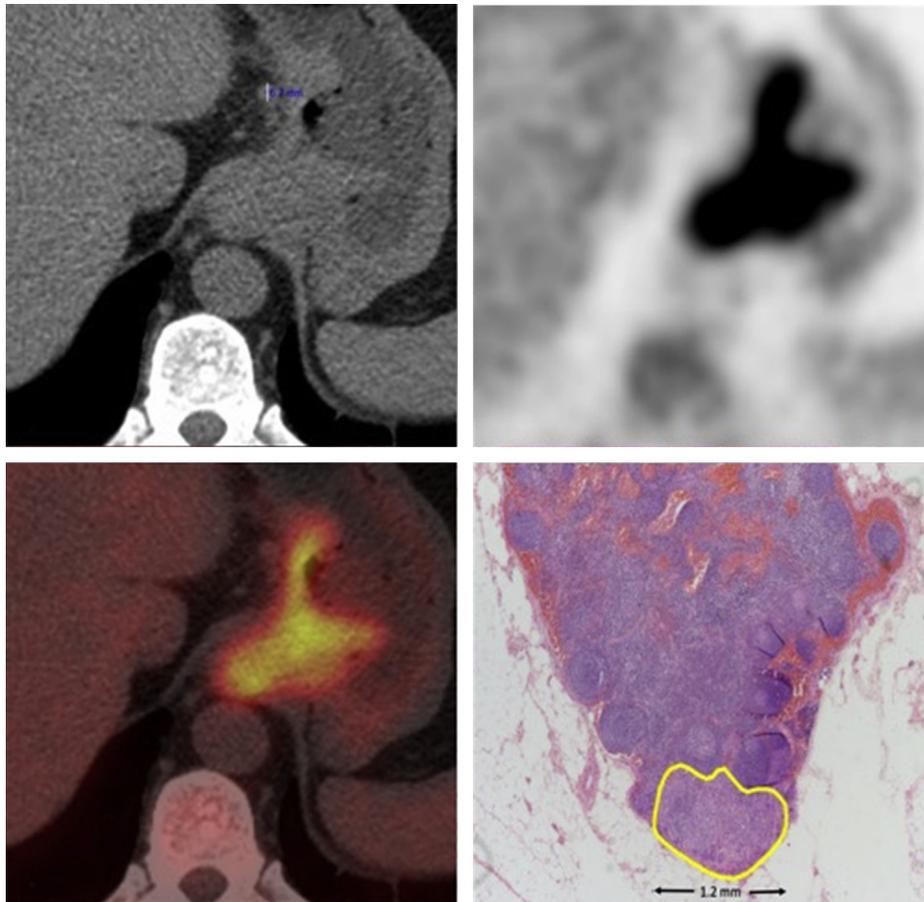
CT (with callipers), PET, and fused PET/CT images of a “false-negative” left gastric lymph node in a patient with junctional adenocarcinoma. A low-power magnification of the lymph node shows a micro-metastasis. For reference, the lymph node measured 5 mm in maximum size and the micro-metastasis (highlighted with yellow outline) measured 1.2 mm.
